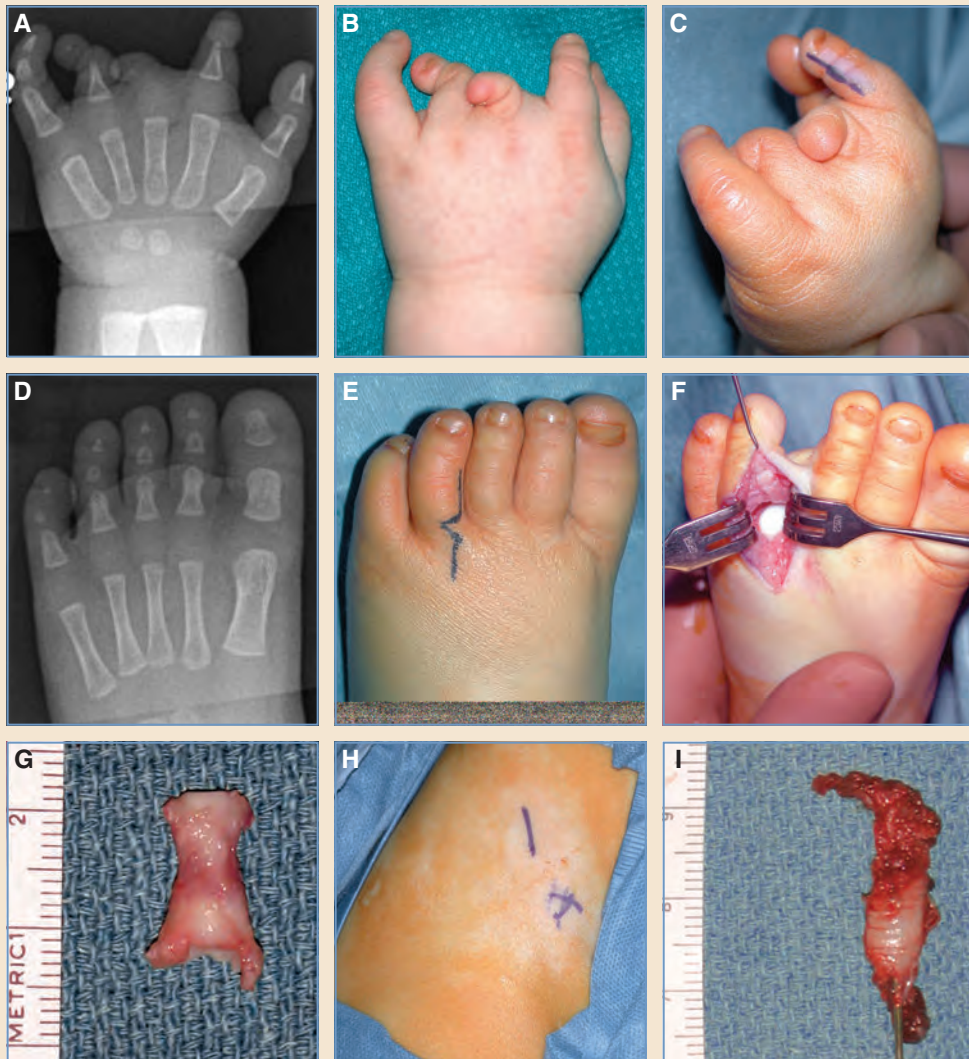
Free toe phalanx transfer to the index finger in symbrachydactyly. A, Preoperative posteroanterior radiograph of the left hand. B, Preoperative appearance of the left hand. The index fingertip is unstable for pinch. C, Planned incision for the free toe phalanx transfer to the monophalangeal index finger to stabilize the flail tip. D, Anteroposterior radiograph of the left foot in which the fourth toe proximal phalanx will be harvested. E, Planned incision for harvesting the fourth toe proximal phalanx. F, The fourth toe proximal phalanx has been removed; the extensor tendon is retracted to the lateral side and the head of the metacarpal is visible in the depth of the wound. G, The fourth toe proximal phalanx has been harvested including the periosteum, proximal collateral ligaments, the plantar plate, and the proximal joint capsule. Unfortunately, despite precise measurements on the preoperative radiographs, the width and length of the phalanx were excessive when attempting its transfer to the index finger and required reduction. During the reduction procedure, the periosteum was kept pedicled to cover the sites of bony reduction. H, The right iliac crest was prepared for harvesting a bone graft to fill the donor defect in the toe. (NOTE: X marks the anterosuperior iliac spine. The incision is planned for just below the iliac crest to prevent a scar in the area subjected to the most friction from clothing, and posterior to the X to avoid branches of the lateral femoral cutaneous nerve.) I, Bone of adequate width and length for the donor defect in the toe, is harvested from the iliac crest with a trepan.
